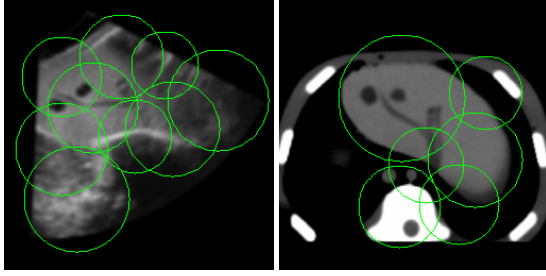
Saliency Regions extracted in US and CT Images.
